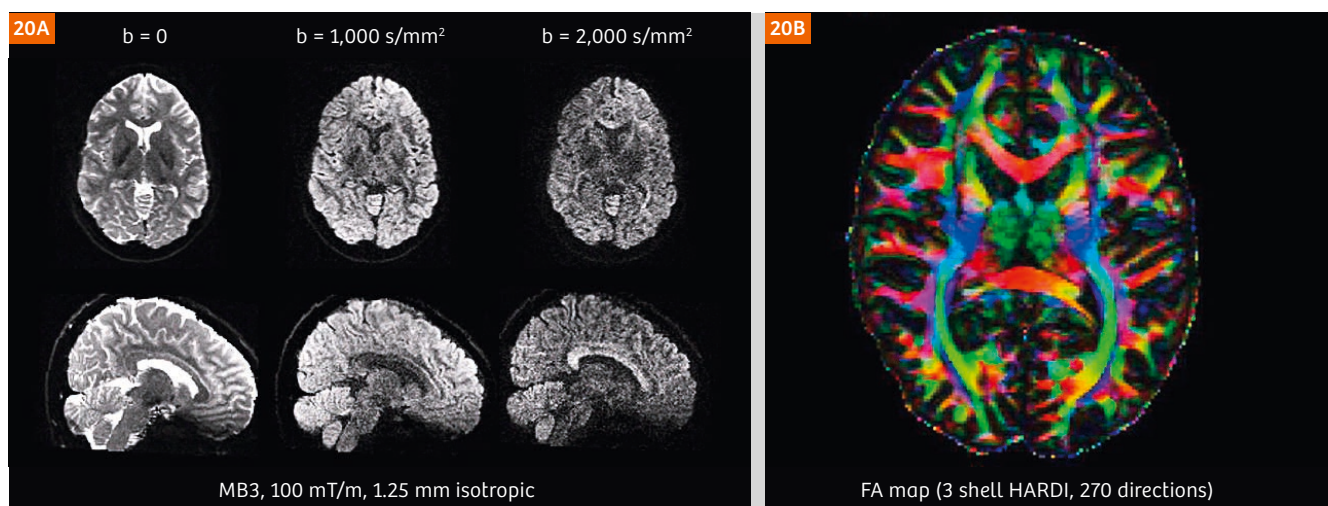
Representative examples of diffusion MRI with the finalized 3T HCP protocol (100 mT/m, MB3, 1.25 mm³ isotropic). Anatomical detail in comparison to a conventional 3T protocol (2 mm³ isotropic, not shown here) is significantly improved. (20A) Image intensities are presented in arbitrary units after distortion correction and averaging across paired phase encoding directions. (20B) Color fractional anisotropy (FA) maps. Colors depict the principal fiber orientation and gray scale intensities are defined by FA. Images courtesy of Washington University – University of Minnesota – Oxford University Human Connectome Project.
